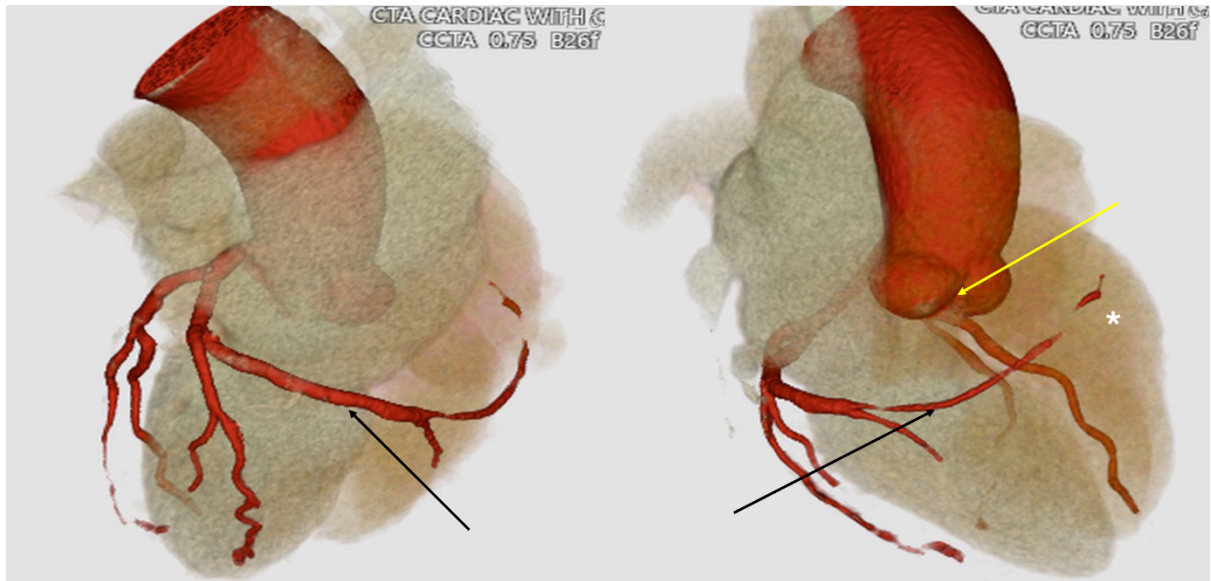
Volume-rendered CT coronary angiography image showing non-visualization of the right coronary artery ostium (yellow arrow). The left circumflex artery (black arrow) continues along the left atrioventricular groove into the right atrioventricular groove to supply the distal right coronary artery territory (*).
